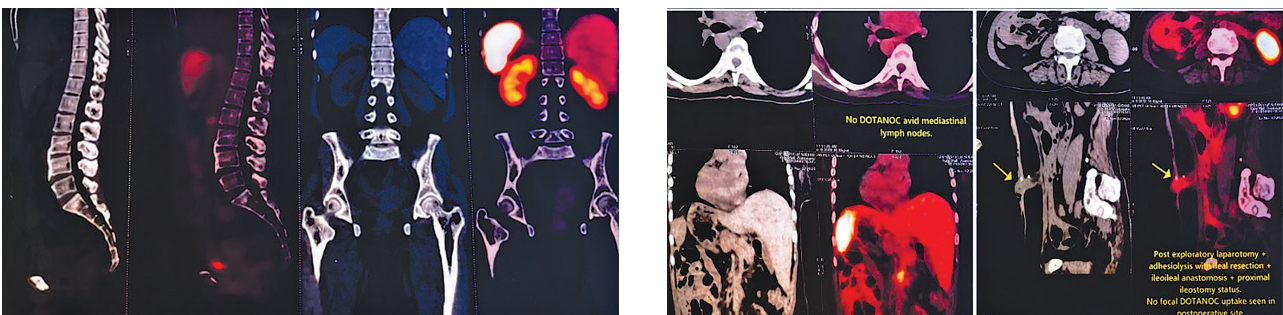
Postoperative Ga-68 DOTANOC PET-CT image showing no focal uptake or abnormal SSTR (somatostatin receptor) expression
